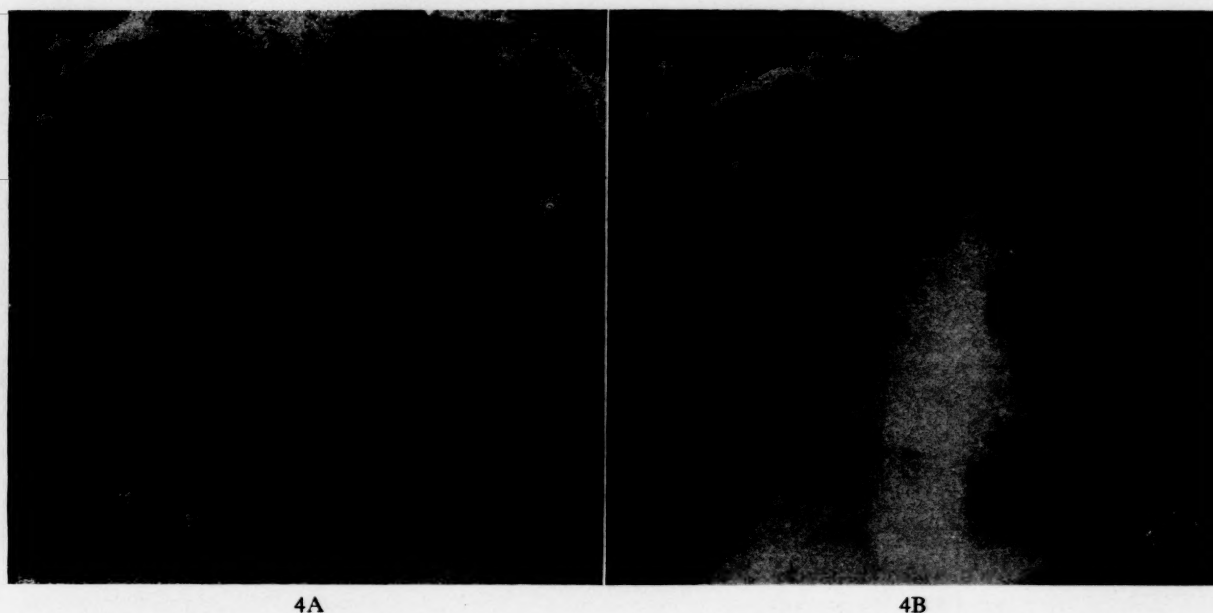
A and B, plain radiograph and angiogram to show post-stenotic dilatation of pulmonary artery.
